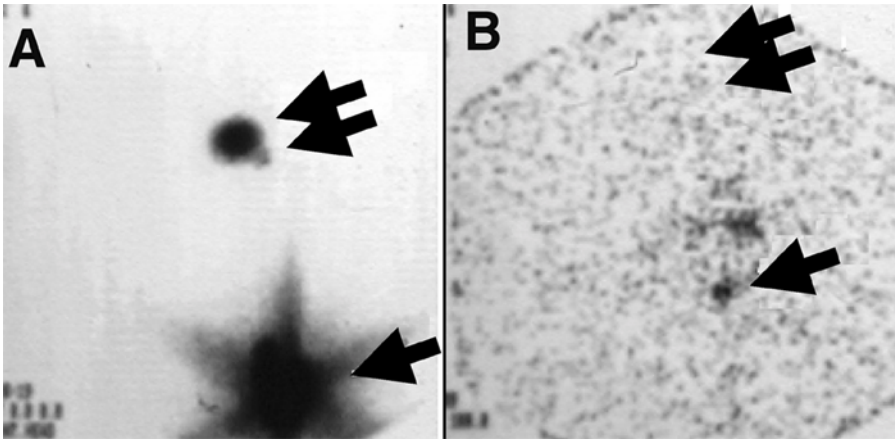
^{131}I whole-body scan of follicular thyroid cancer metastatic to the skull. After thyroidectomy and dosimetry, the patient was treated with a maximal dose of 350 mCi of ^{131}I with resolution of metastatic uptake in bone. A plain film of the skull was normal. Patient's Tg levels were subsequently unmeasurable with or without levothyroxine suppression. (A) ^{131}I uptake into skull metastasis and secretion into nasooropharynx. (B) Resolution of ^{131}I uptake into skull lesion. Single arrow: physiologic secretions of RAI into nasooropharynx. Double arrows: follicular carcinoma metastatic to skull.
